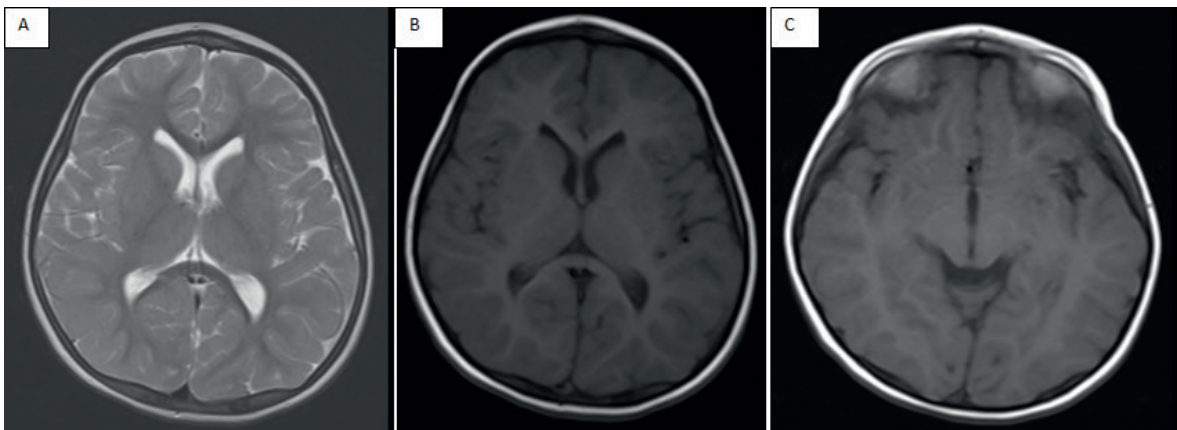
Brain MRI at 45 months of age shows no evidence of iron deposition. A: T2 Axial Globus Pallidus section, B: T1 Axial Globus Pallidus section, C: T1 Axial Substantia Nigra section.
